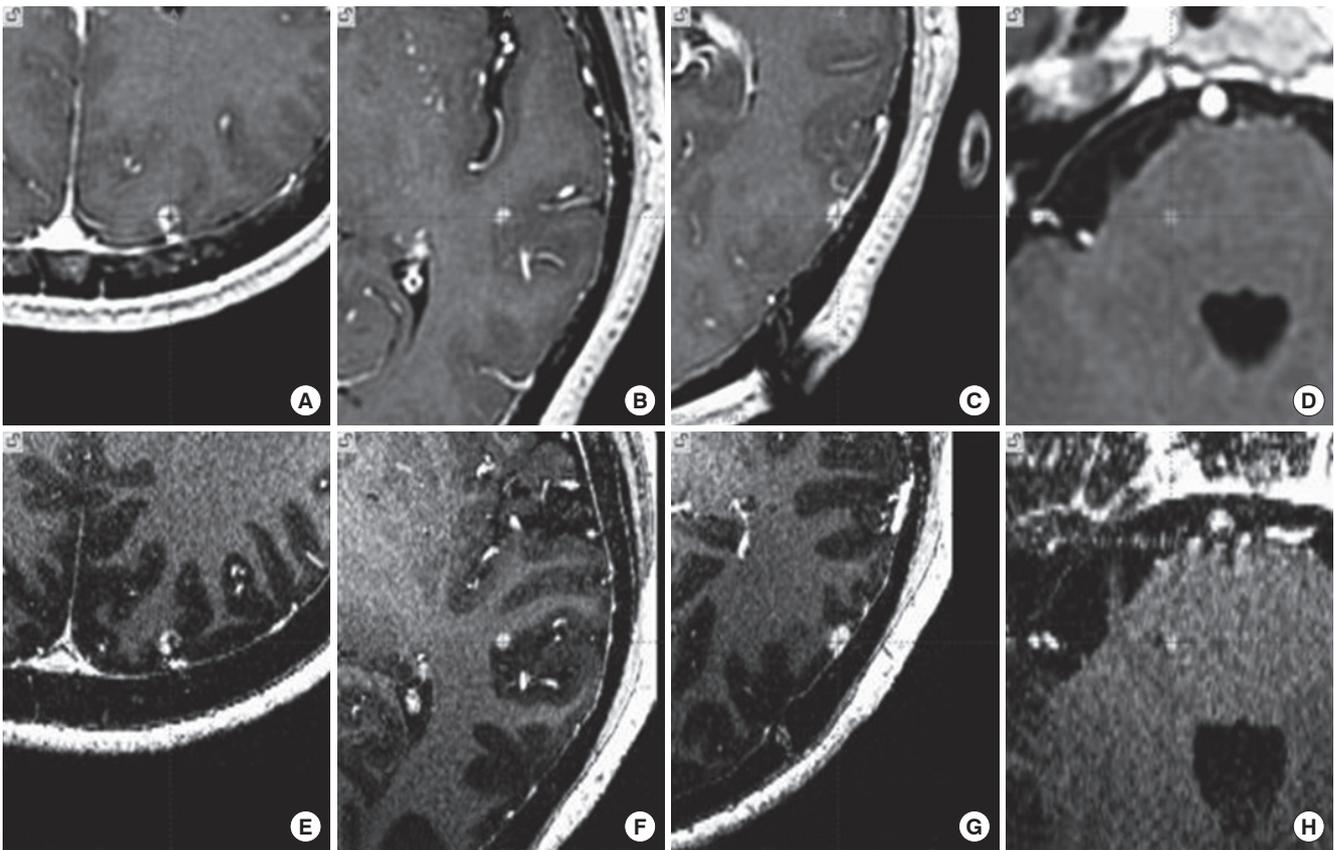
Axial images of four metastatic brain tumors in the co-registered images of 1.5 T and 7.0 T magnetic resonance images (MRI). Upper panel shows 1.5 T MRI (A-D) and lower panel shows 7.0 T MRI (E-H). Total four metastatic brain tumors are found; three lesions in the left parietal (A, E) and temporal lobe (B, C, F, G) and one in the right side of the pons (D, H).
